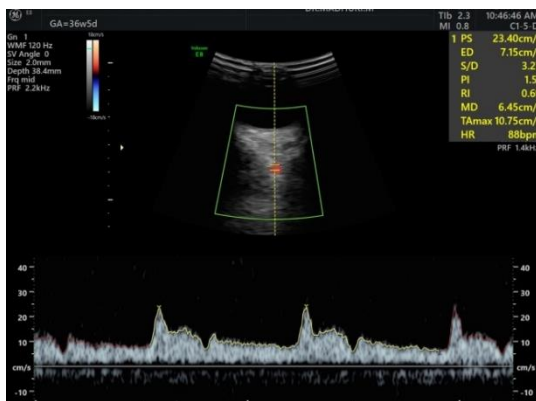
Representative image of ophthalmic artery doppler waveform in a normotensive woman.
